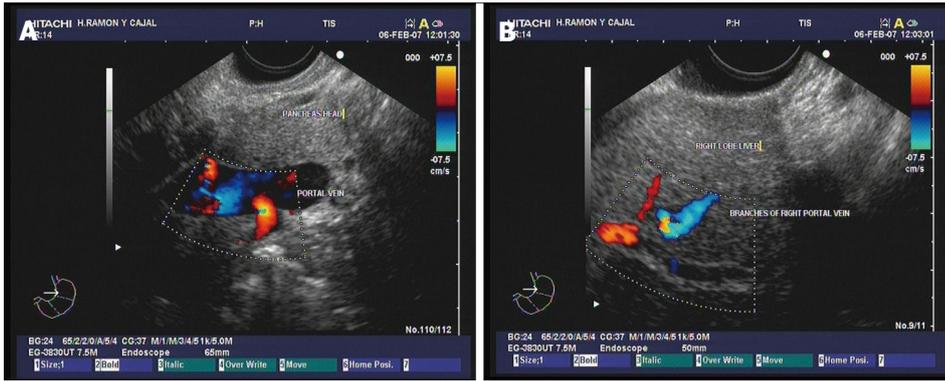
Doppler ultrasound images. A: The main portal vein show adequate blood flow; B: Vein flow is also evidenced by interrogation of the branches of the right portal vein at the intrahepatic level. Images courtesy of Grupo Español de Protocolos en Endoscopia Digestiva.
